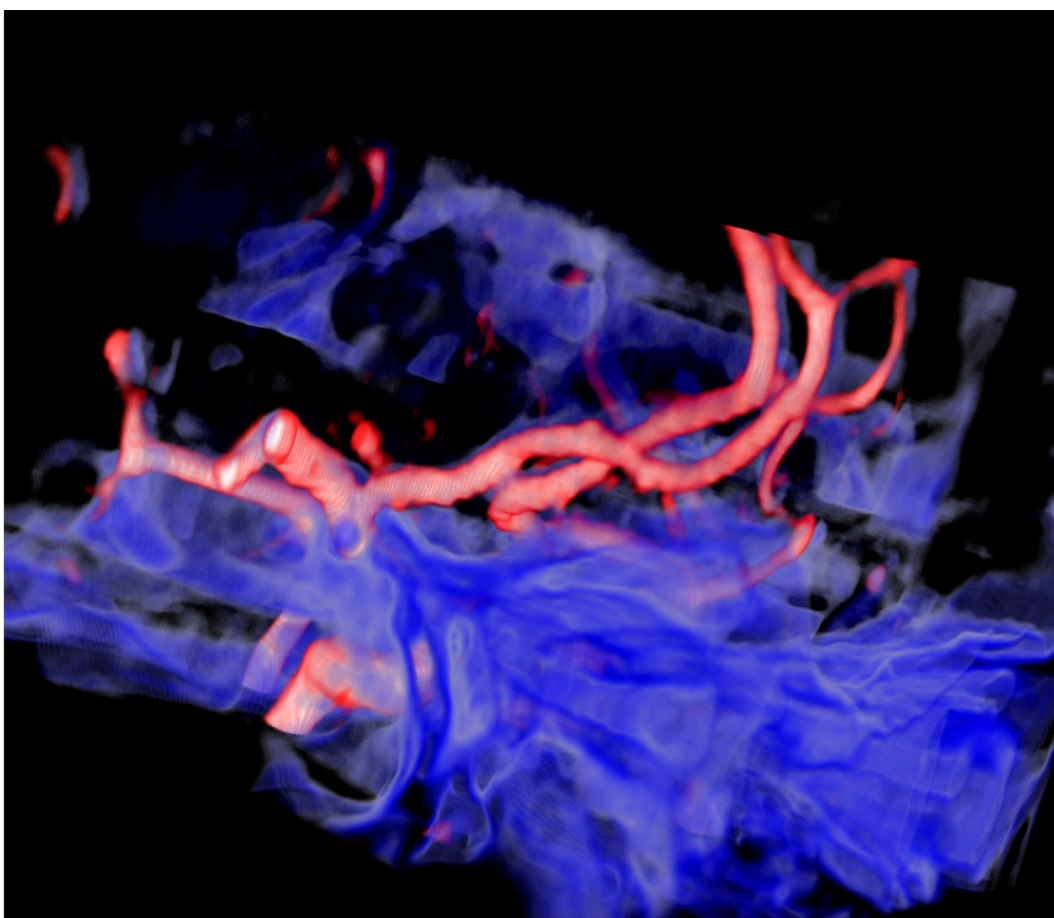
Results Aneurism 1. Volume renderings of MRI T1 (*blue*) and MRA (*red*) before registration.
